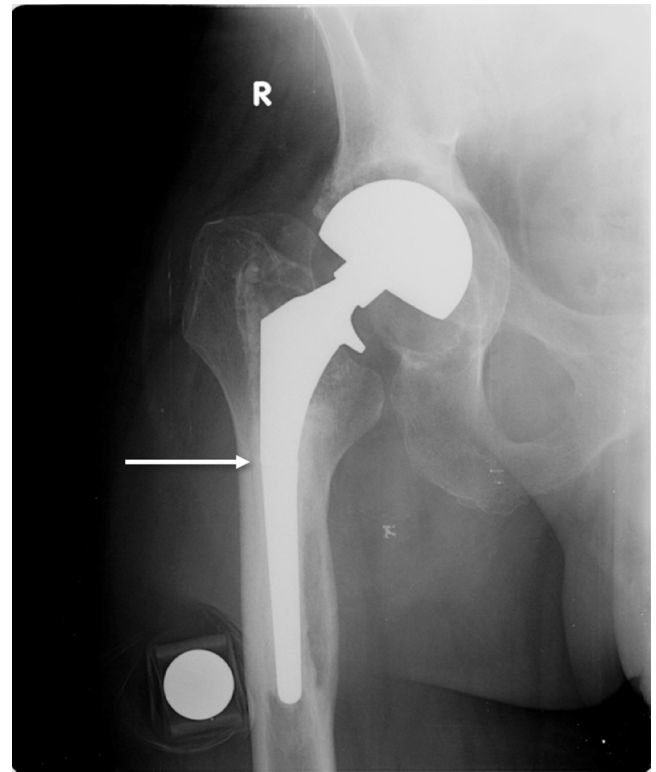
Radiograph of the primary implant reveal a mid-stem fracture, acetabular osteolysis, proximal implant migration, and a loose cement mantle. The location of fracture is denoted by the white arrow.
